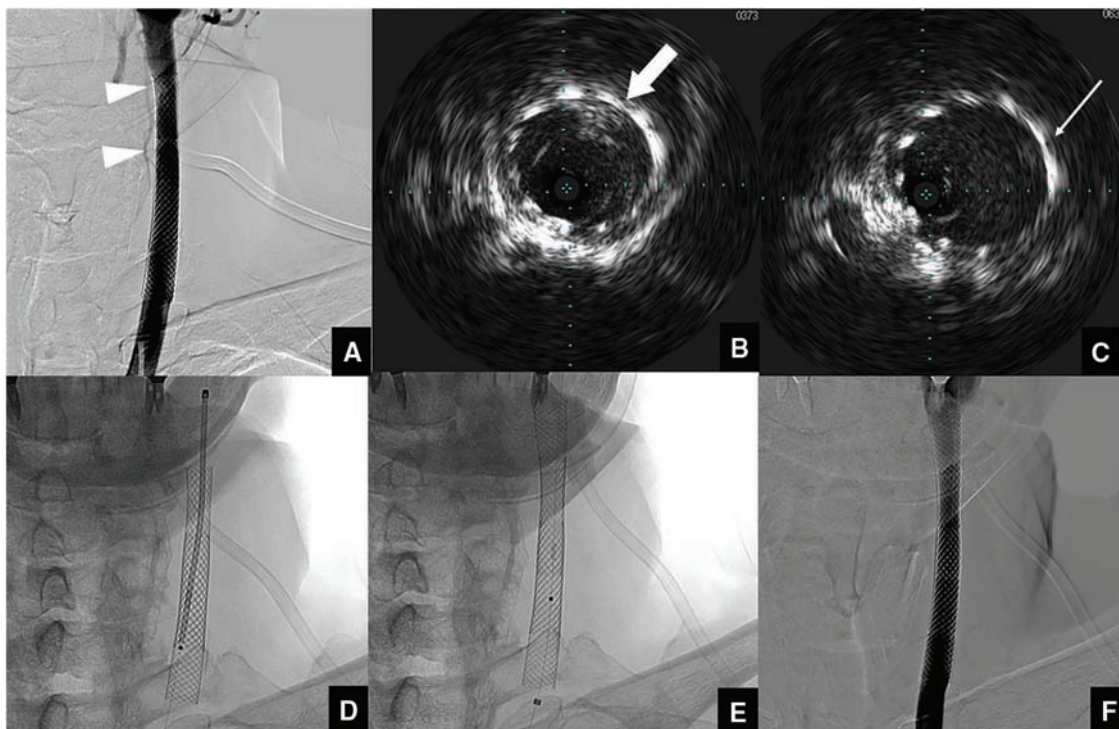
(A) Left common carotid angiography before additional CAS (frontal view) showing plaque protrusion (white arrowheads). (B) IVUS before placement shows plaque protrusion at the distal end of the Carotid Wallstent in the direction of 1 o'clock (thick white arrow). (C) IVUS after stent placement shows plaque protrusion at the site of overlap in the direction of 2 o'clock (thin white arrow). (D) Fluoroscopic image before stent placement. (E) A 10 mm x 31 mm Carotid Wallstent was placed to cover the plaque protruded area. (F) Left common artery injection showed no contrast-enhanced defect. CAS: carotid artery stenting; IVUS: intravascular ultrasonography
